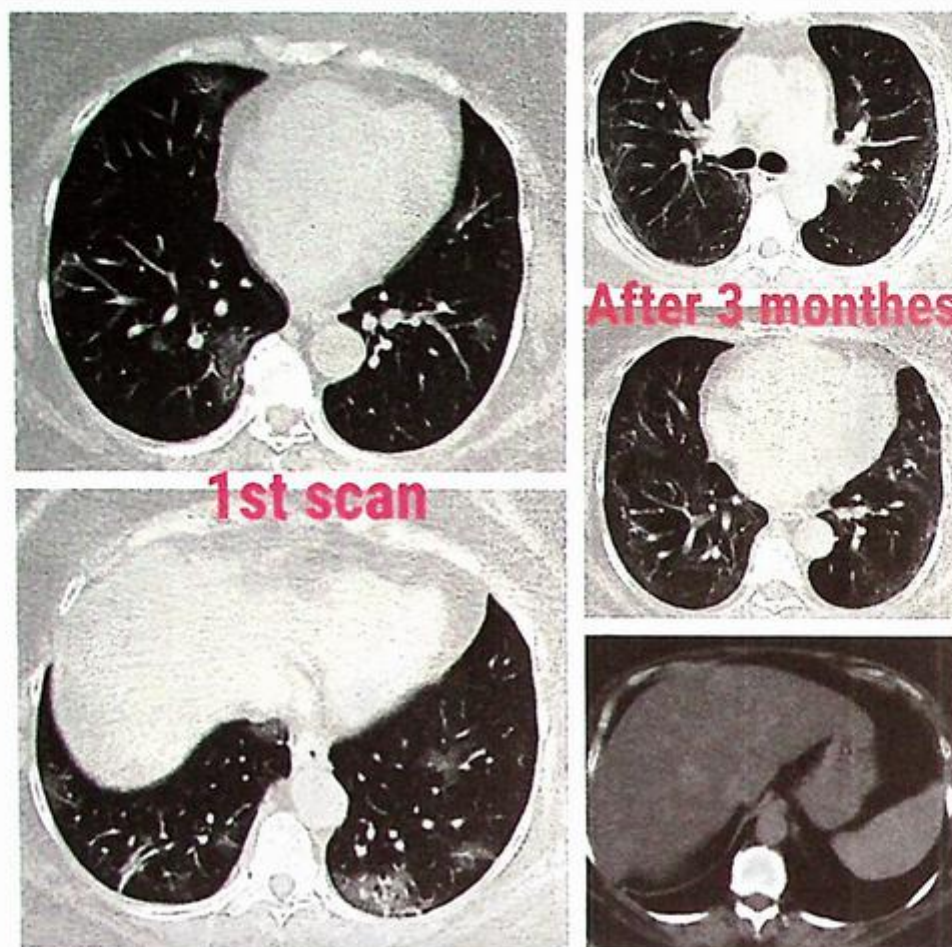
Female patient, 28 years old. CT chest shows multiple pulmonary ground-glass opacities mounting to consolidative patches, reported as CORADs 5. Upper abdominal cuts show diffuse low parenchymal attenuation of the liver denoting fatty infiltration
